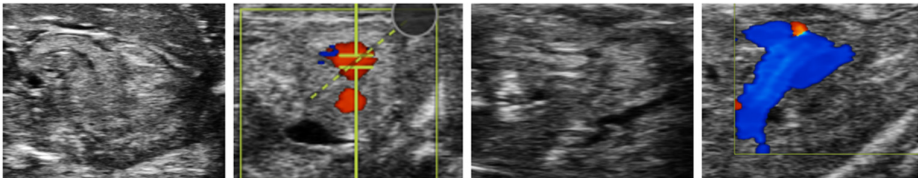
From left to right: (1- long-axis B-Mode localized at ventricles, 2- short-axis Doppler of the right ventricle outflow tract, 3- long-axis B-Mode localized at the pulmonary artery, 4- long-axis Doppler of the pulmonary artery outflow tract).
